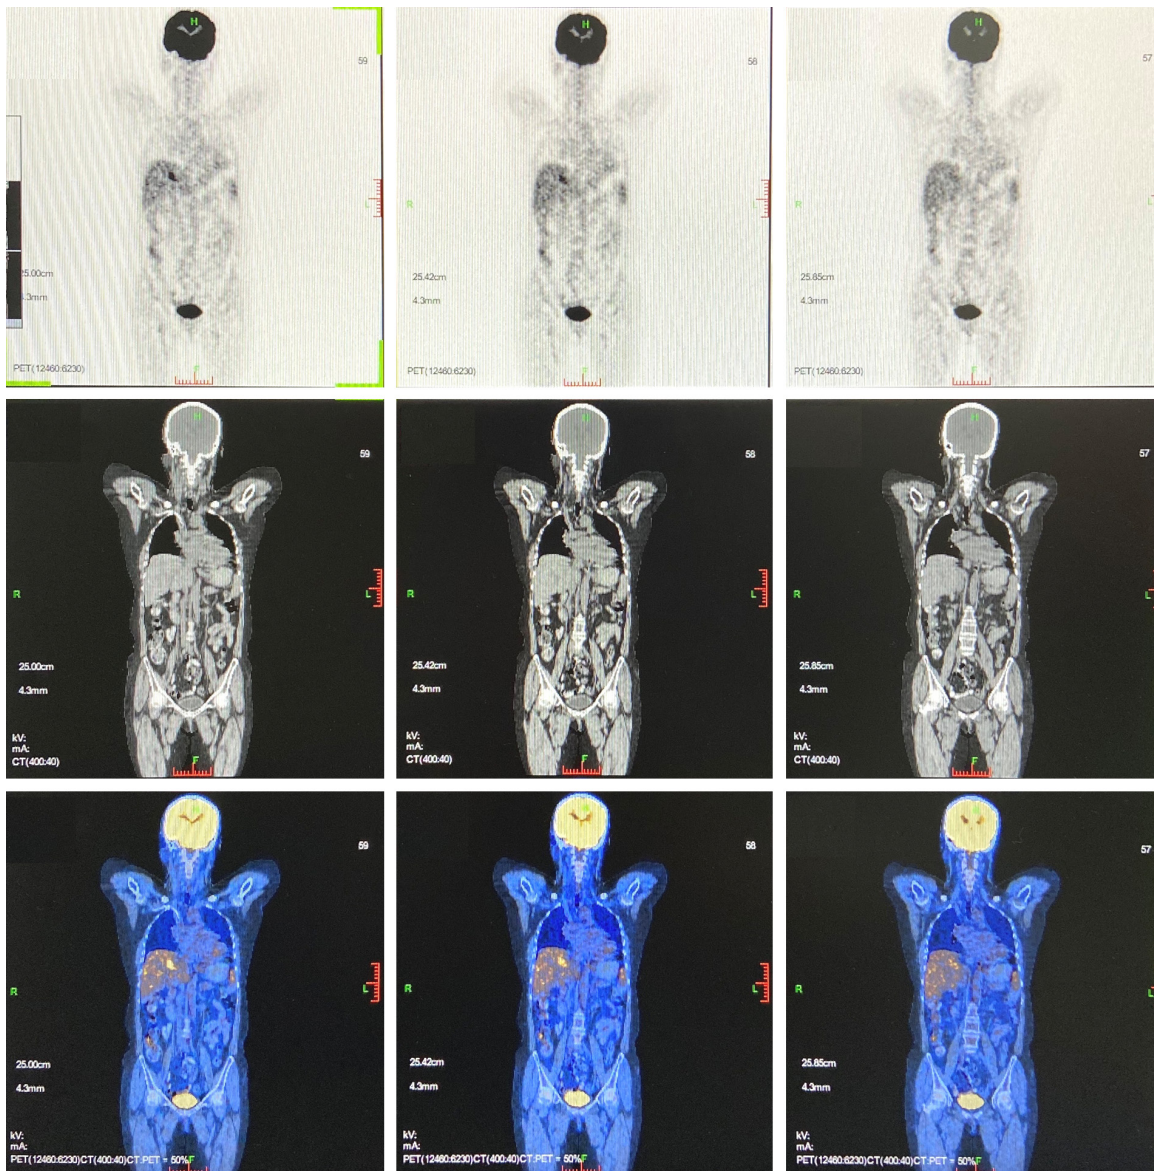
The PET-CT image of patient 1 after chemotherapy for assessment of condition. PET-CT showed: 1. Changes after heart transplantation; 2. Diffuse large B-cell lymphoma imaging, residual flakes in the right lung lesions, activity was suppressed, and the residual active lesions in the S8 segment of the liver were smaller than before.
